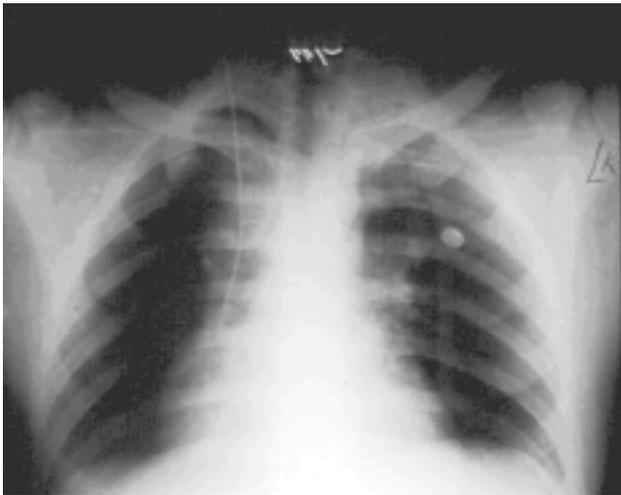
X-ray of thorax of the first patient in shock.
